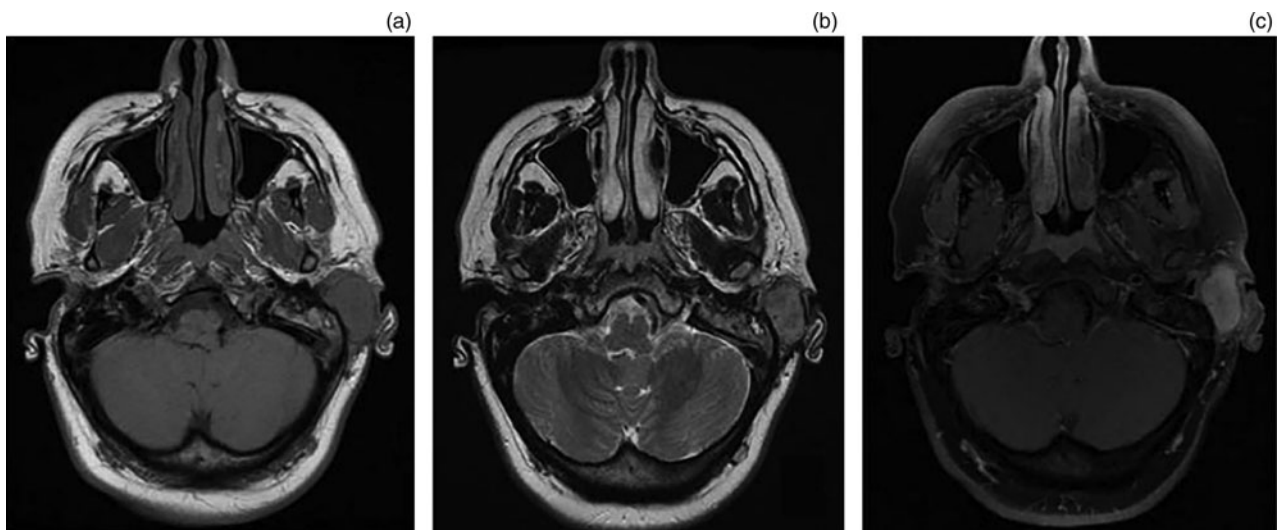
(a) T1-weighted, (b) T2-weighted and (c) T1-weighted plus gadolinium axial magnetic resonance imaging scans.
